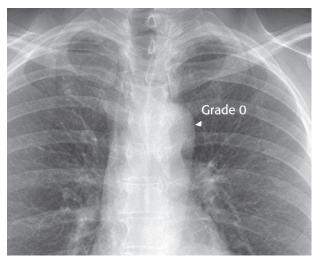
A posterior-anterior chest radiograph showing the aortic knob (arrow) on the left side of the mediastinal shadow. Grade 0, no visible calcification.
